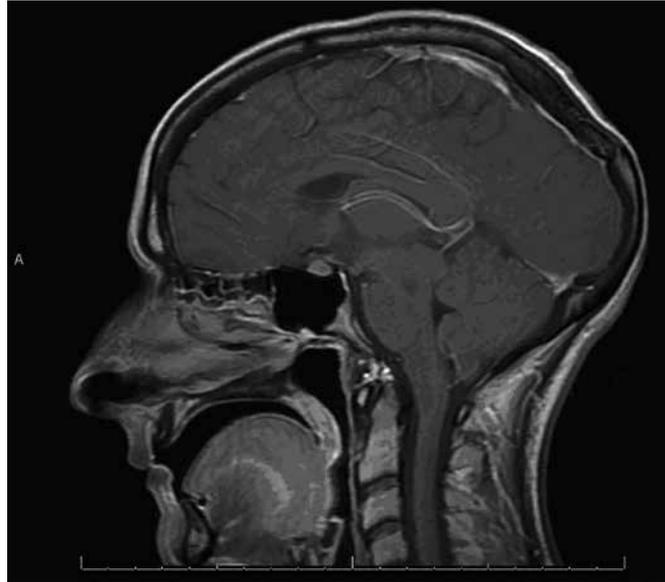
Sagittal T1-weighted magnetic resonance imaging of the brain demonstrating mild downward slumping of the midbrain consistent with intracranial hypotension.
